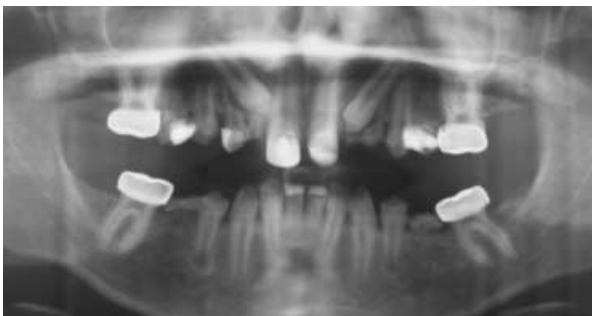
Orthopantomographic radiograph taken when the subject was aged 11.5 years: note that the development of 14 has continued, but lags behind 24, which is at the apex complete stage of development.
